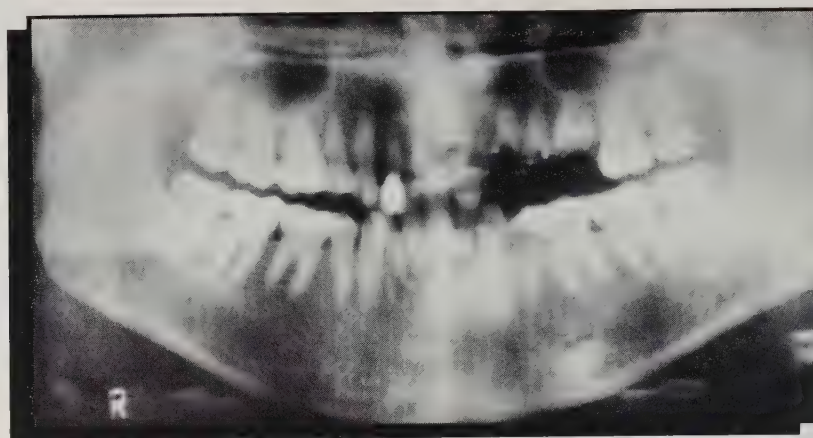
Post-accident panoramic radiograph showing multiple fractured and avulsed maxillary teeth and partially avulsed lower incisors.
